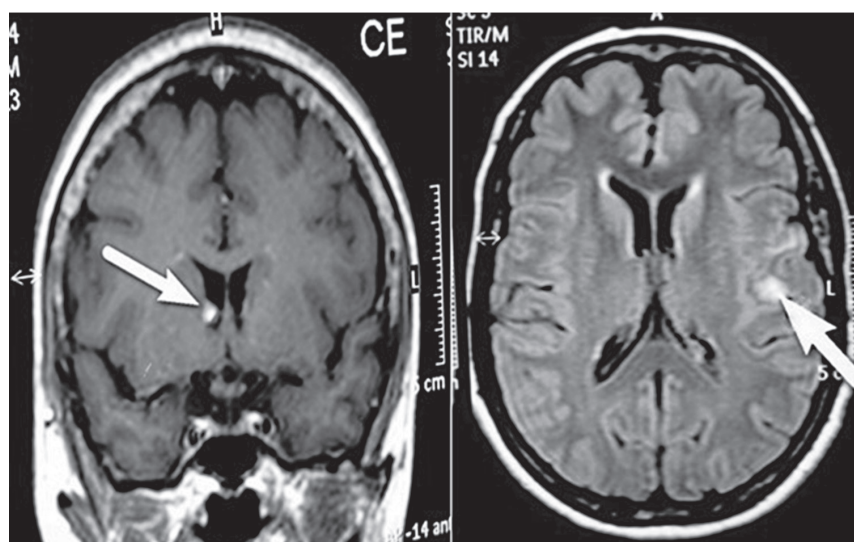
Brain magnetic resonance imaging (MRI) showing a small subependymal nodule and cortical tuber.
